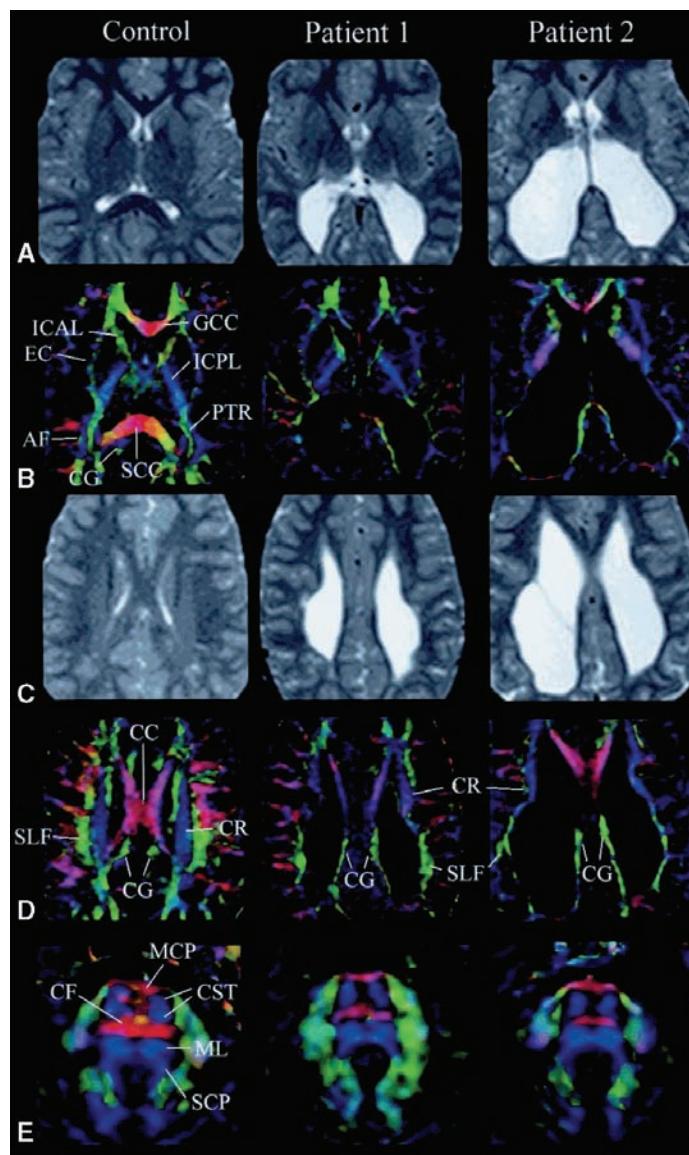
(A) and (C) T2-weighed images and (B), (D), and (E) diffusion tensor MRI (DTI)-based color maps at three axial slice levels of the eight-year-old control and patients 1 and 2. On the color maps, red color represents tracts oriented in the right-left direction, green anterior-posterior, and blue superior-inferior. (B) The ICAL was similar in controls and subjects, but posterior fibers in the ICPL, posterior CC, and PTR are decreased in size. (D) At the level of the CR, the posterior CR was not seen in subjects, but was clearly present in controls. The posterior CC was also severely affected. (E) The CST in the brain stem was similar in controls and subjects. Major identifiable structures are annotated. Abbreviations: CST, corticospinal tract; MCP, middle cerebellar peduncle; SCP, superior cerebellar peduncle; CF, crossing fiber; ML, medial lemniscus; ICAL/ICPL, anterior/posterior limb of internal capsule; EC, external capsule; AF, arcuate fasciculus; PTR, posterior thalamic radiation; CC, corpus callosum; GCC, genu of corpus callosum; SCC, splenium of corpus callosum; CR, corona radiata; CG, cingulum; SLF, superior longitudinal fasciculus.
